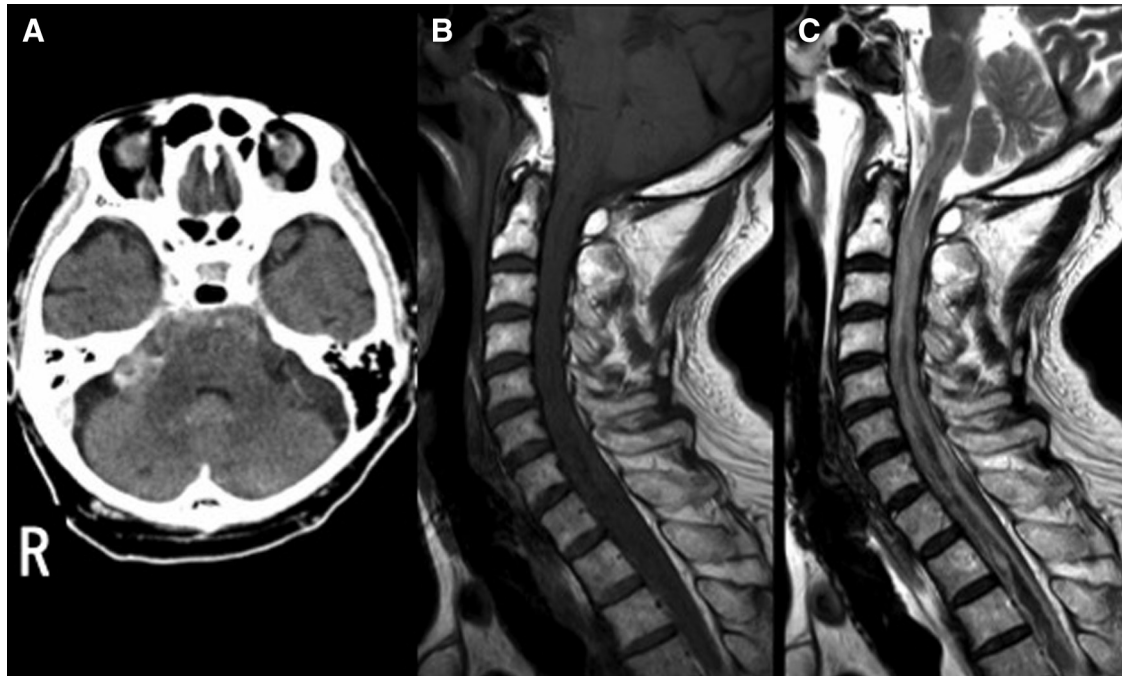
Head CT (A) showed no change in subarachnoid hemorrhage, but cervical MRI (B, T1-weighted image; C, T2-weighted image) demonstrated bleeding from the spinal cord into the subarachnoid space. CT: computed tomography; MRI: magnetic resonance imaging
